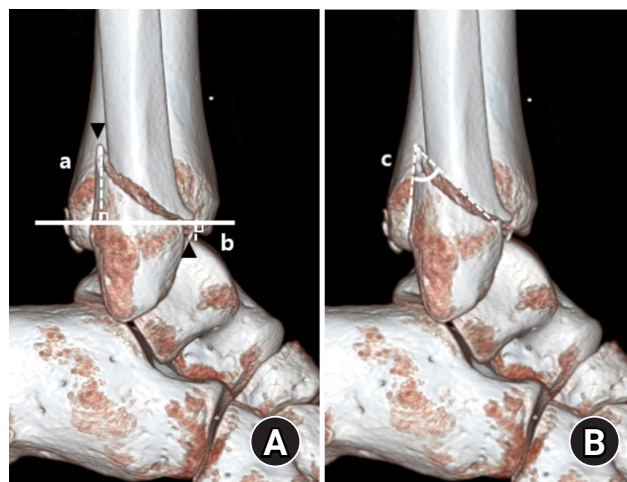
Radiographic assessment of fracture characteristics. (A) Posterior height (a) and anterior height (b) represent the vertical distances from the highest point of the posterior cortex (▼) and the lowest point of the anterior cortex (▲) of the distal lateral fibula, respectively, to the line perpendicular to the tibial axis that intersects the distal tibial articular plafond. (B) The fracture angle (c) of the lateral malleolar fragment is defined as the angle between the posterior cortex of the lateral malleolus and the line connecting the anterior and posterior cortical points of the fracture.
